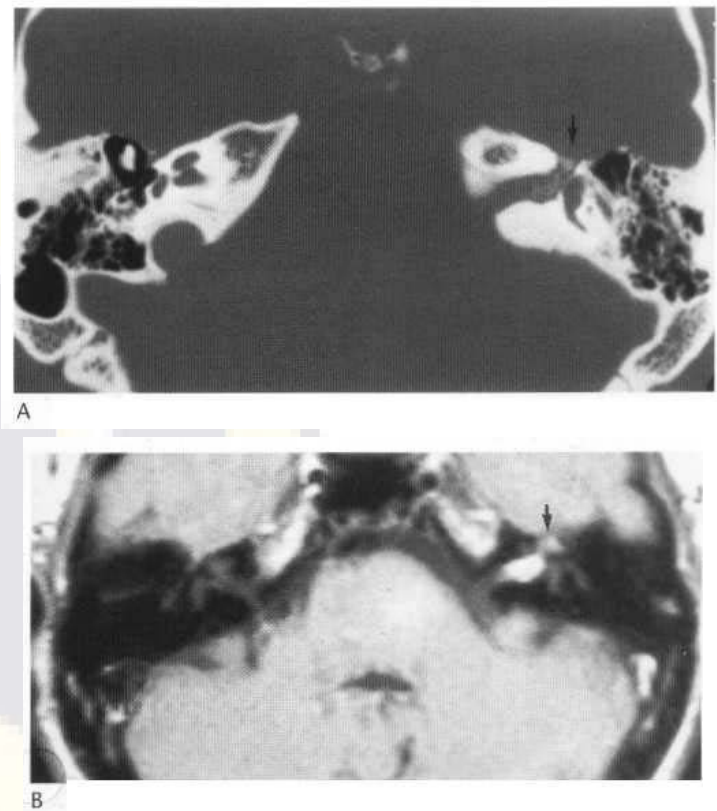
(A) Axial CT section through the IAM showing expansion of the first part of the facial nerve canal (arrow). Note the calcification which should have suggested that this was a haemangioma rather than a neuroma. (B) Axial MR section, T₁-weighted with gadolinium enhancement, shows the mass (arrow).
